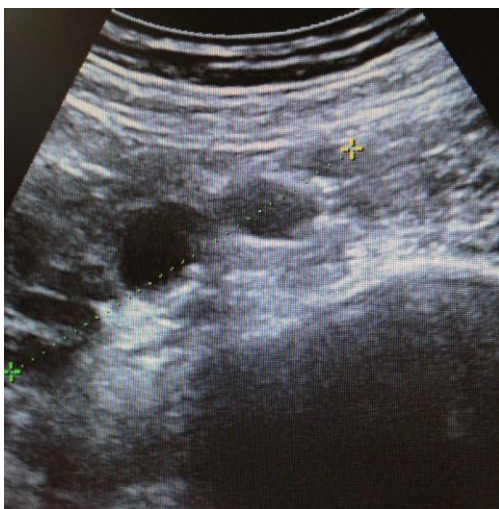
Transabdominal ultrasonography showing a multilocular cyst with incomplete septation
